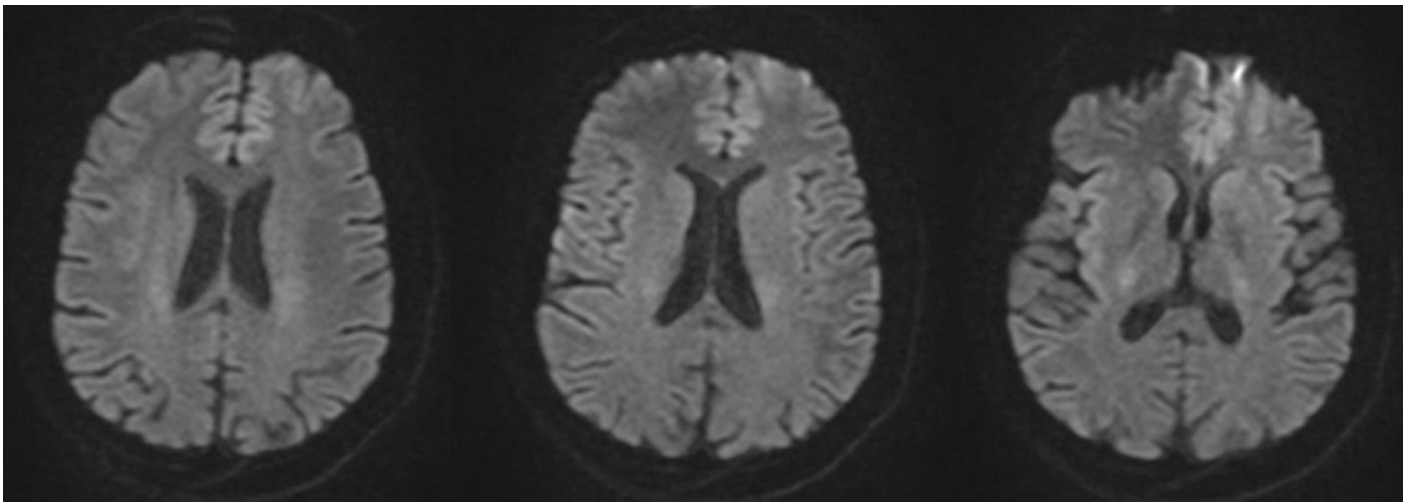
Control diffusion MRI in the eighth month showing no ischemia in the regions revealing diffusion defects in the previous MRI.
